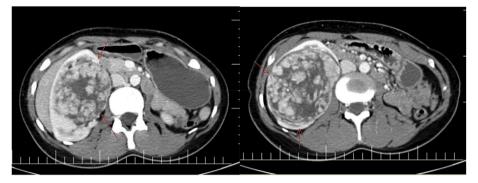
Contrast-enhanced computed tomography of the thoraco-abdomen revealed a 10 cm sized mass lesion with necrotic changes and milimetrical calcifications in the right kidney (arrows).
